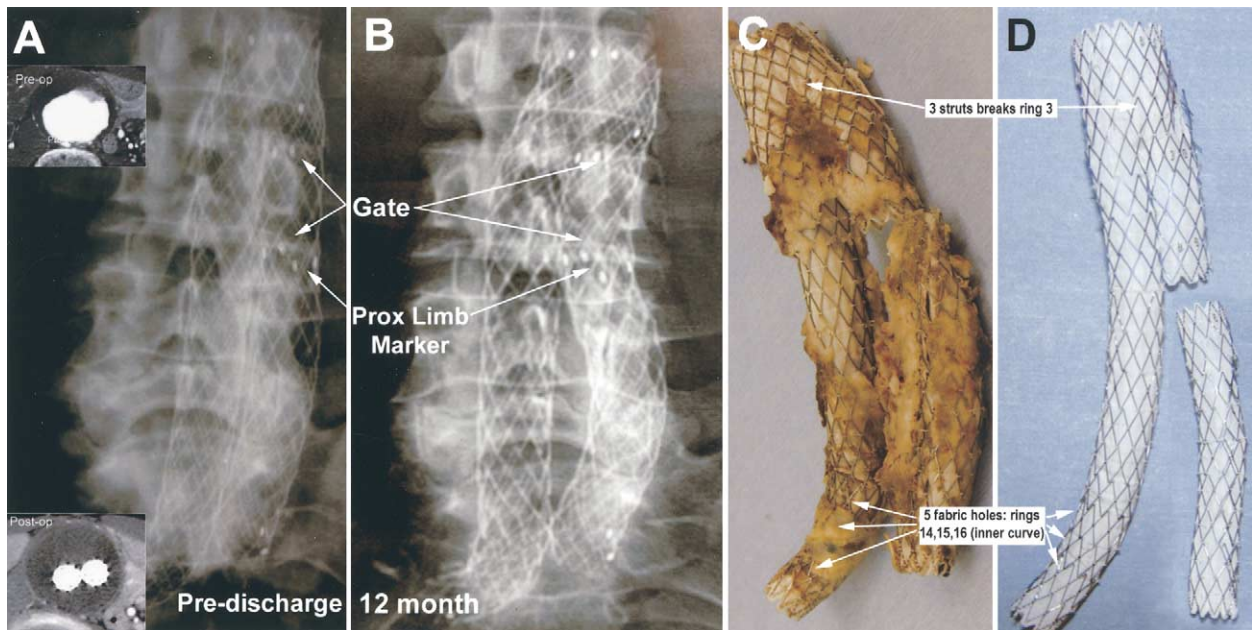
Explant case example. A, A $24 \times 14 \times 16.5$ -cm-long bifurcation module was implanted through the right femoral artery to treat a 5.5-cm abdominal aortic aneurysm. A 14×8.5 -cm-long left iliac limb was used and positioned below the bifurcation junction gate (see markers). The left iliac limb was too short, and barely reached the left iliac artery. The aneurysm was successfully excluded from the circulation, with no evidence of endoleak (see inserts). However, insecure fixation both proximally and distally of the left iliac limb was apparent on the x-ray film. B, Bowing of the left iliac limb and slight angulation of the bifurcation module was apparent on x-ray film at 12 months. There continued to be no endoleak, and no change in aneurysm size. C, Aneurysm ruptured at 21 months as a result of separation of the iliac limb from the bifurcation module. The AneuRx stent graft was explanted during successful surgical conversion. D, Explant analysis revealed fatigue fractures in ring 3 of the bifurcation module (*top arrows*), and fabric holes in the angulated right iliac limb at rings 14 to 16, remote from the aneurysm sac (*bottom arrows*). There were no abnormalities in the left iliac limb.
